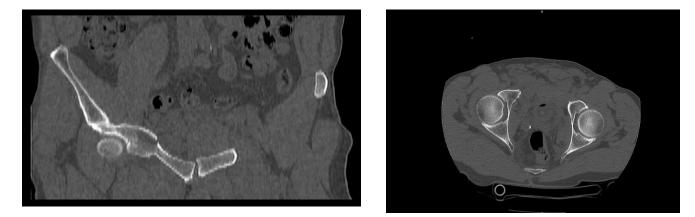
CT-Scan shows fracture of the right superior ramus of the pubis.
